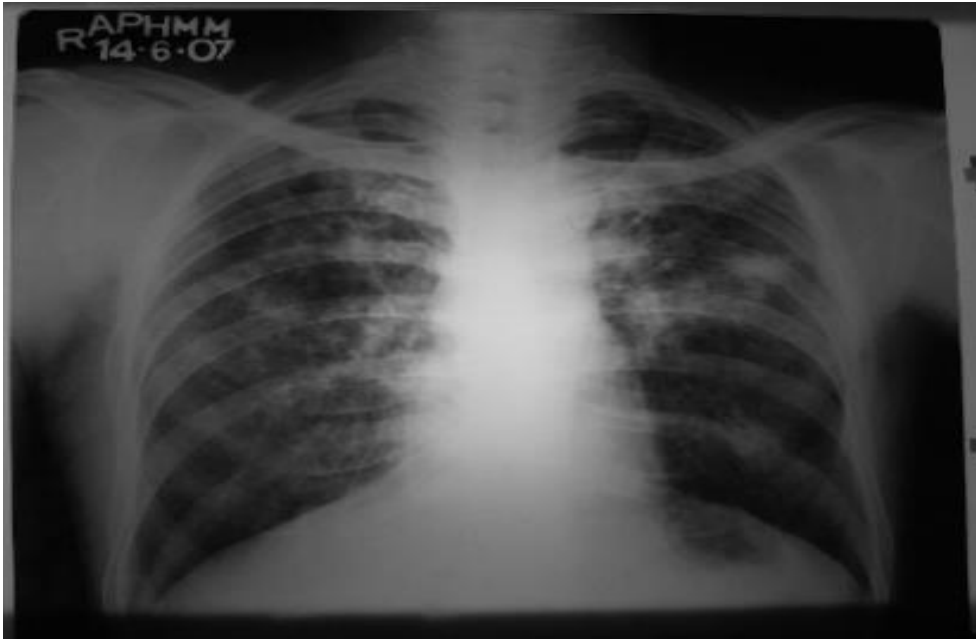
Chest radiograph shows signs of consolidation.
